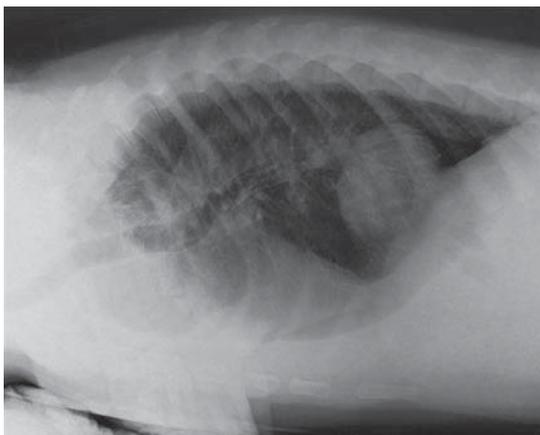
Lateral thoracic radiograph with abnormal soft tissue opacity in the caudal thorax.
